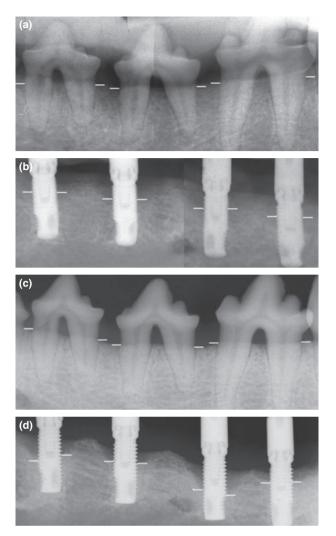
Radiographs from tooth and implant sites obtained at ligature removal (baseline) (a, b) and at biopsy (26 weeks) (c, d). The arrows indicate bone levels.
